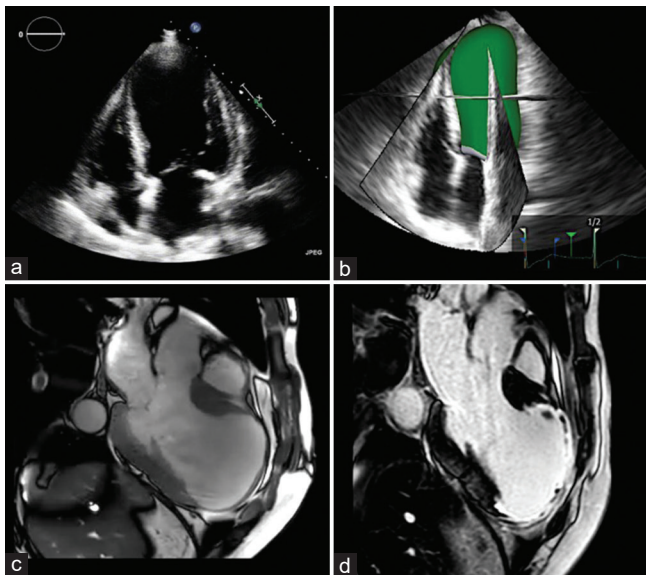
Case of ischemic heart disease in a patient hospitalized for subacute myocardial infarction. (a) Transthoracic echocardiography, apical four-chamber view: dilatation and severe systolic dysfunction of the left ventricle, along with a large apical aneurysm, which is associated with a higher risk of sudden cardiac death. (b) Three-dimensional transthoracic echocardiography allows for a more accurate assessment of biventricular volumes and function. (c) Cardiac magnetic resonance, cine steady state free precession imaging, three-chamber view: the presence of a large apical aneurysm is confirmed. (d) Cardiac magnetic resonance, post contrast imaging, three-chamber view, showing the presence of extensive late gadolinium enhancement at the level of the apical aneurysm.
